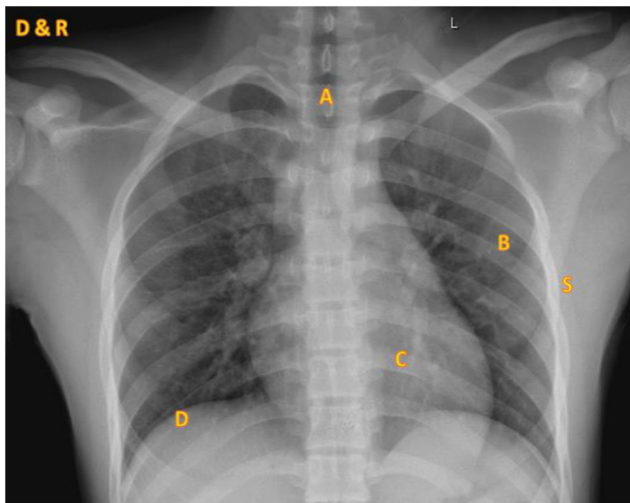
Interpretation of X-ray chest: D: details (demographics, type of film, time and date); R: RIPE (assess image quality); S: soft tissue and bones: look for subcutaneous air and # of ribs, sternum, clavicle and scapulae. A: airway and mediastinum; B: breathing lung fields pneumothorax, pulmonary contusion, cavitation; C: circulation. Heart size, shape; D: diaphragm shape, angle, subdiaphragmatic air, gastric bubbles; E: extra. Endotracheal tube, central venous catheters, intercostal tubes
